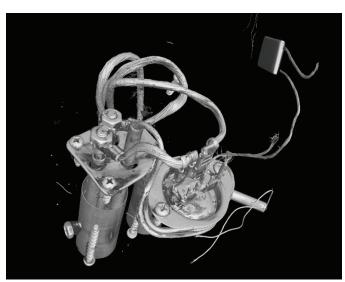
CT scan showing PTC heater and capillary tubing.
